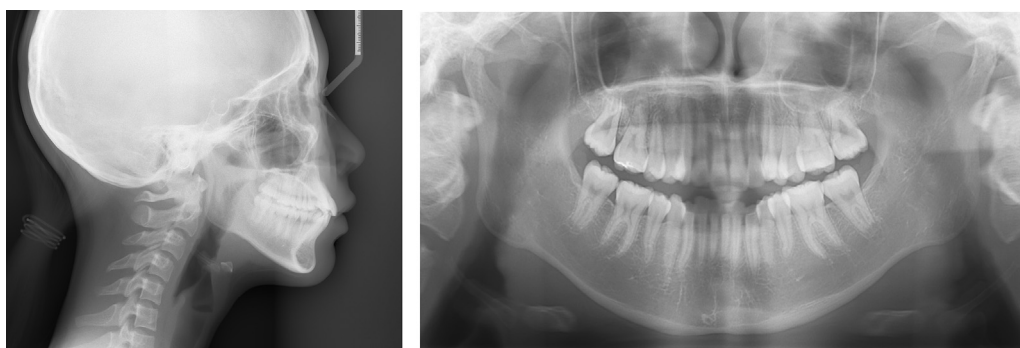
Pretreatment lateral cephalogram and panoramic radiograph (patient aged 13 years 8 months).
